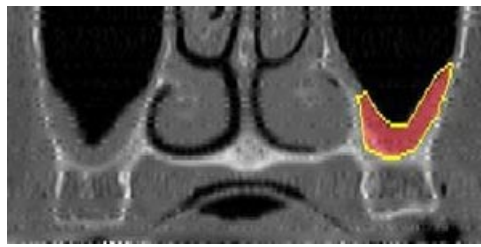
CT-image of a patient treated with periosteum derived tissue engineered bone
